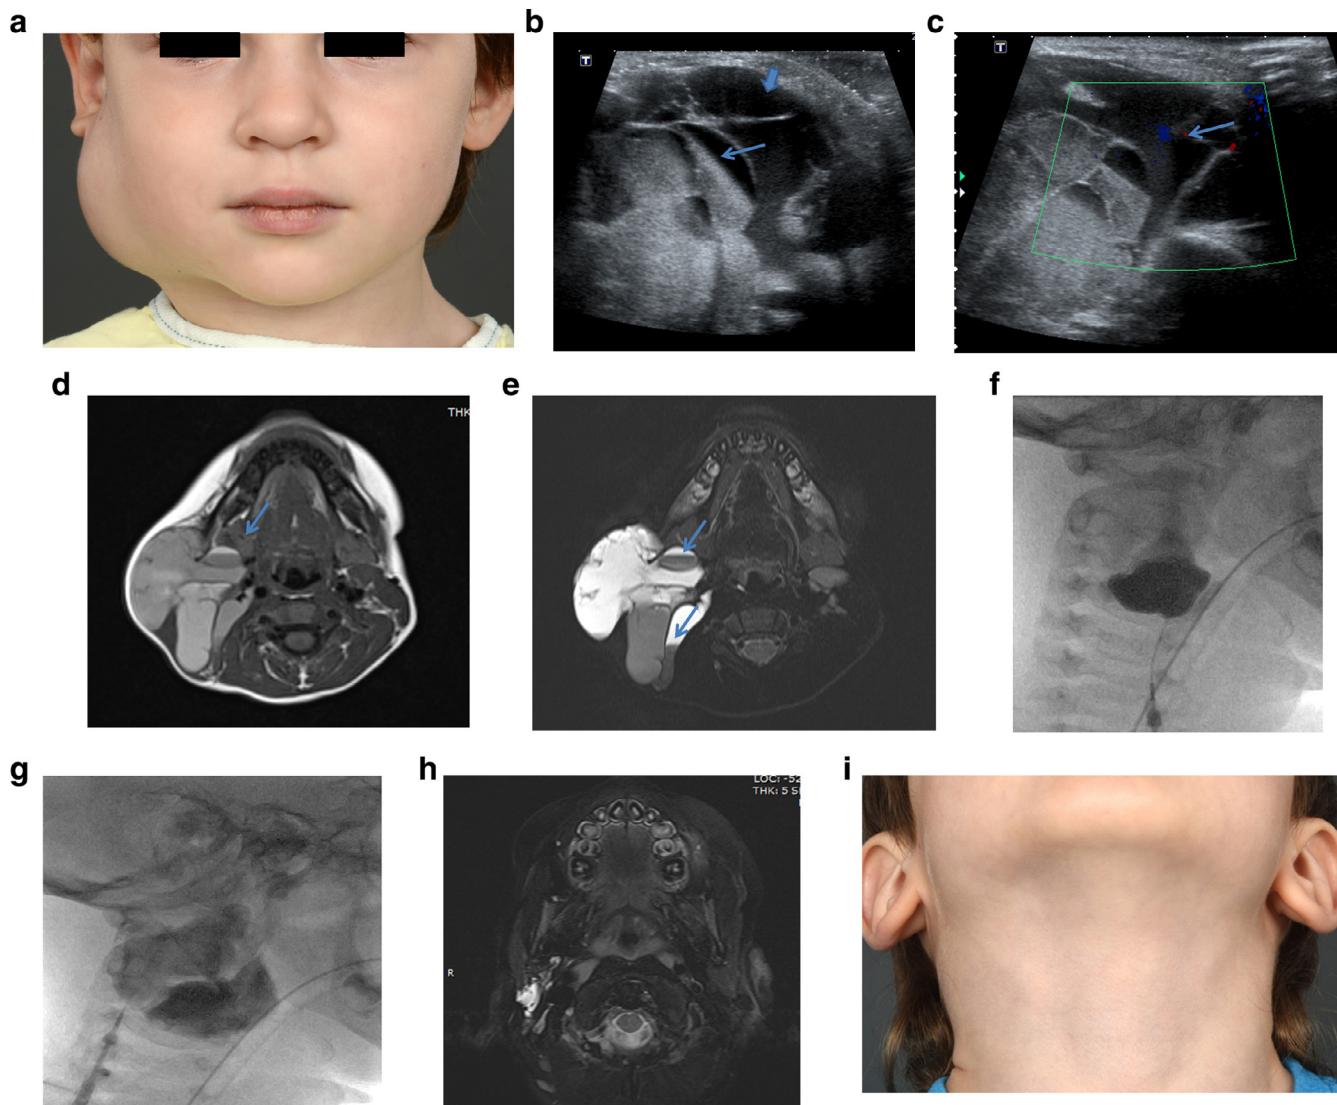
(a) Three-year-old boy with sudden apparition of a cervical lesion. (b) US demonstrated a multicystic lesion. Some cysts were hyperechoic with fluid-fluid levels due to hemorrhage (arrow) and others were anechoic (arrowhead). (c) Color Doppler revealed vessels in the septa (arrow). (d) Axial T1-W image showed a well-defined multiseptated mass in the parapharyngeal space behind the submandibular gland (arrow), hyperintense compare to the muscle due to the presence of hemorrhage. (e) Axial T2-W FS showed the multicytic lesions with hyperintense content and fluid-fluid levels (arrows). (f, g) Sclerotherapy was performed under general anesthesia. Two punctures were performed under US and fluoroscopy. Fluoroscopy capture showed (i) first puncture with injection of 6 cc (60 mg) of doxycycline and (ii) second puncture with 7 cc (70 mg) of doxycycline. (h) Two years after sclerosing treatment, MRI showed a small residual behind the parotid gland. (i) The patient had no visible lesion in his neck.
